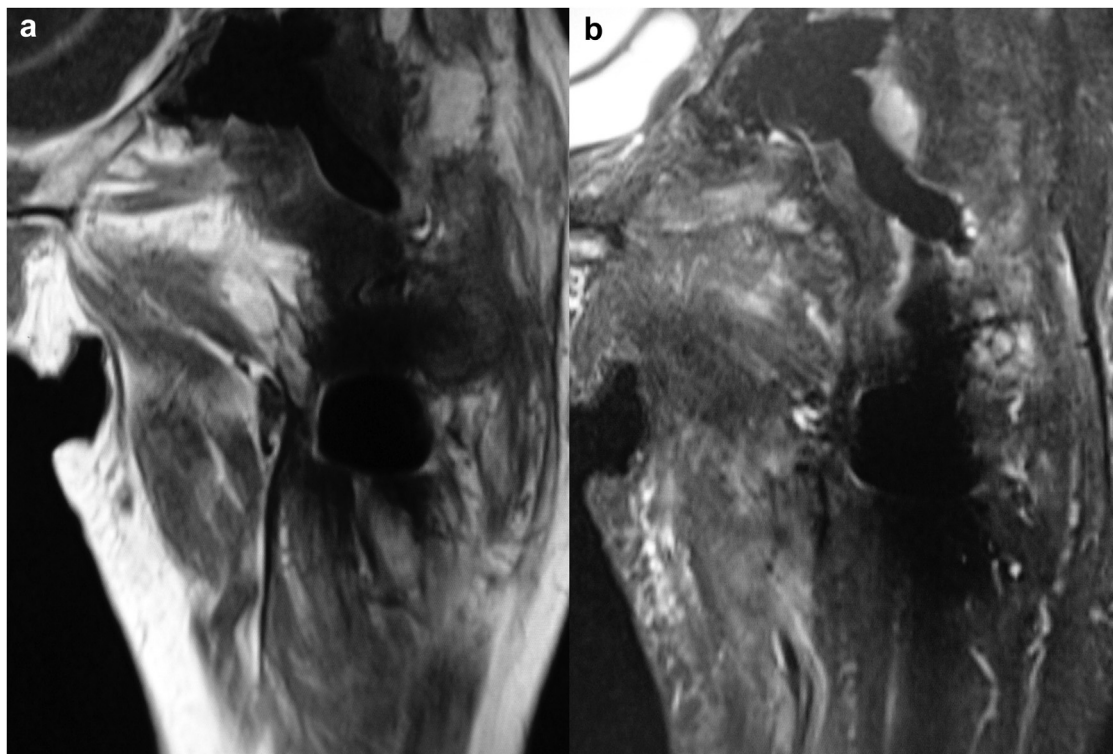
Postoperative MRI.
